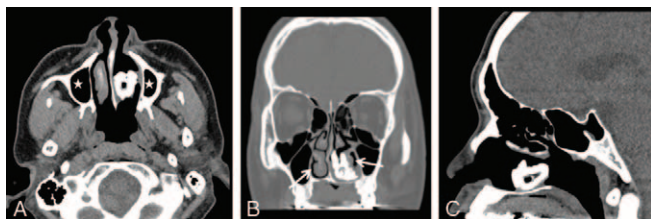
CT scans show a metallic high-density mass with irregular calcification and air trapping but without any involvement of paranasal sinuses. In addition, nasal septal deviation to the right side, poor development of the inferior turbinate (white arrow), and hypopneumatization of the maxillary sinus (asterisk) in comparison with the contralateral side are observed. A, Axial view; B, coronal view; C, sagittal view.
